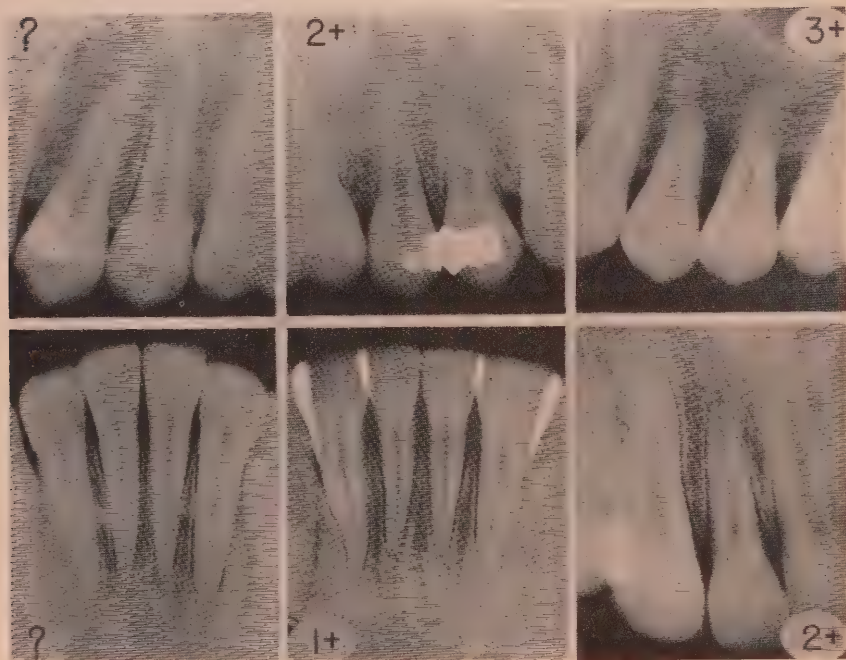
Radiographies illustrant des degrés différents de résorption idiopathique des racines des dents permanentes.
